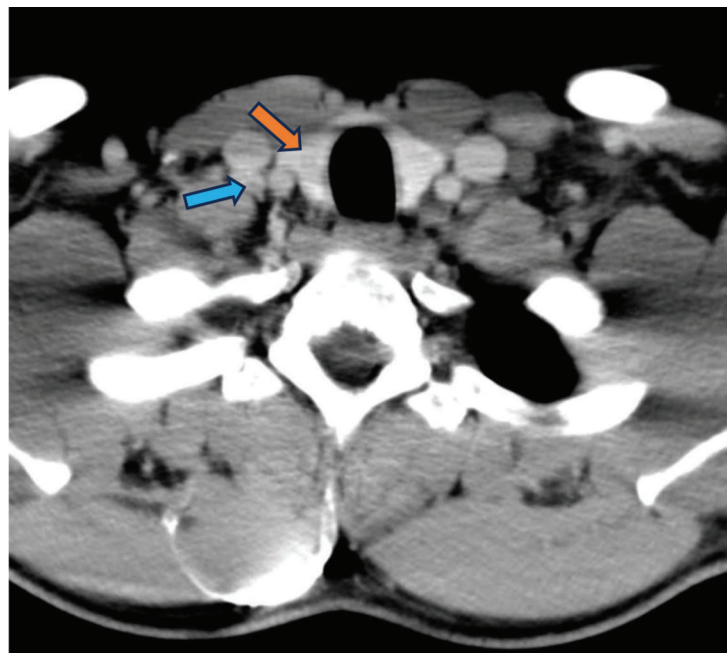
Neck CT scan (transverse view). A small hypodense nodule in the right thyroidal lobe (orange arrow) and an enlarged lymph node (blue arrow).
